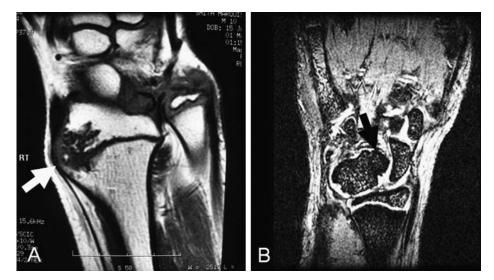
A, Coronal T1-weighted MRI demonstrating a transphyseal lesion spanning the distal radial epiphysis. Note the expanded and irregularly contoured physis adjacent to the apparent physeal bridge (white arrow). B, Coronal T2-weighted MRI image demonstrating a large solitary osteochondroma of the lunate (black arrow). The more radial carpals are spared. MRI indicates magnetic resonance imaging.
